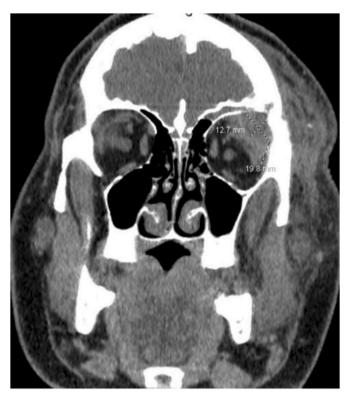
Text: Coronal cut of second maxillofacial CT showing minimal change from previous in the size of the left orbital abscess involving the lacrimal gland with small left upper eyelid component, frontal bone erosions, and intracranial extension.
